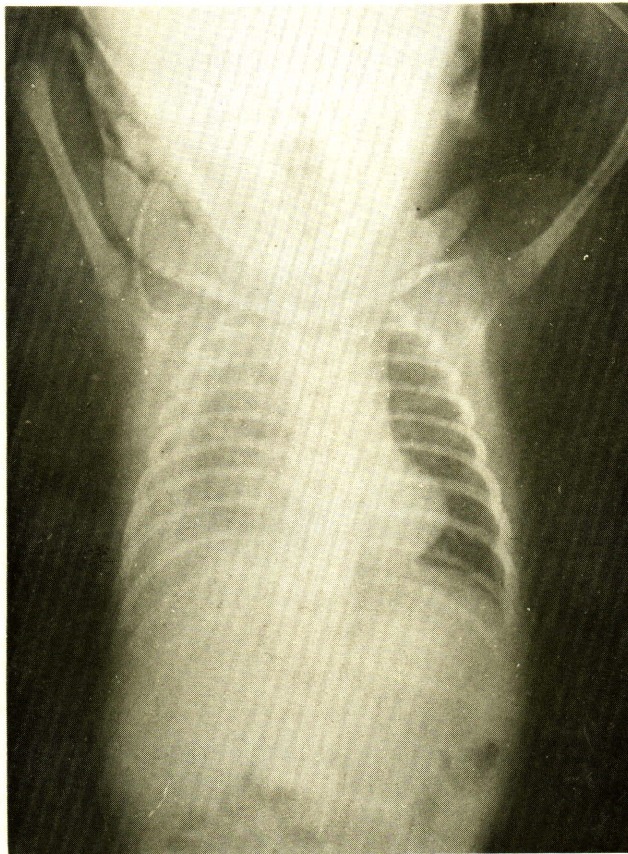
Chest x-ray film taken on the 9th day of life showed significant increase in Rt. pleural effusion.
